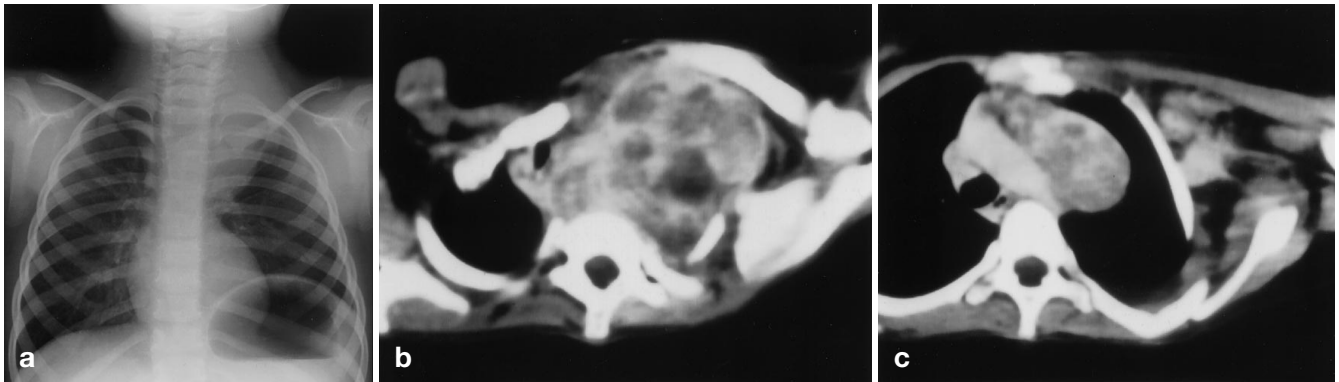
Case 1. a AP chest radiograph at 4 years of age. Large left cervicothoracic ganglioneuroblastoma causes displacement of the trachea towards the right. There is associated elevation of the left hemidiaphragm due to involvement of the left phrenic nerve. b, c Enhanced CT scan through upper thorax at 14 years of age. Large left cervicothoracic mass of heterogeneous attenuation as a result of development of a malignant peripheral nerve-sheath tumor in a ganglioneuroma. The mass crosses midline and causes narrowing and marked deviation of the trachea towards the right (a). It extends inferiorly to the level of the aortic arch and left axillary lymphadenopathy is also noted (b)
